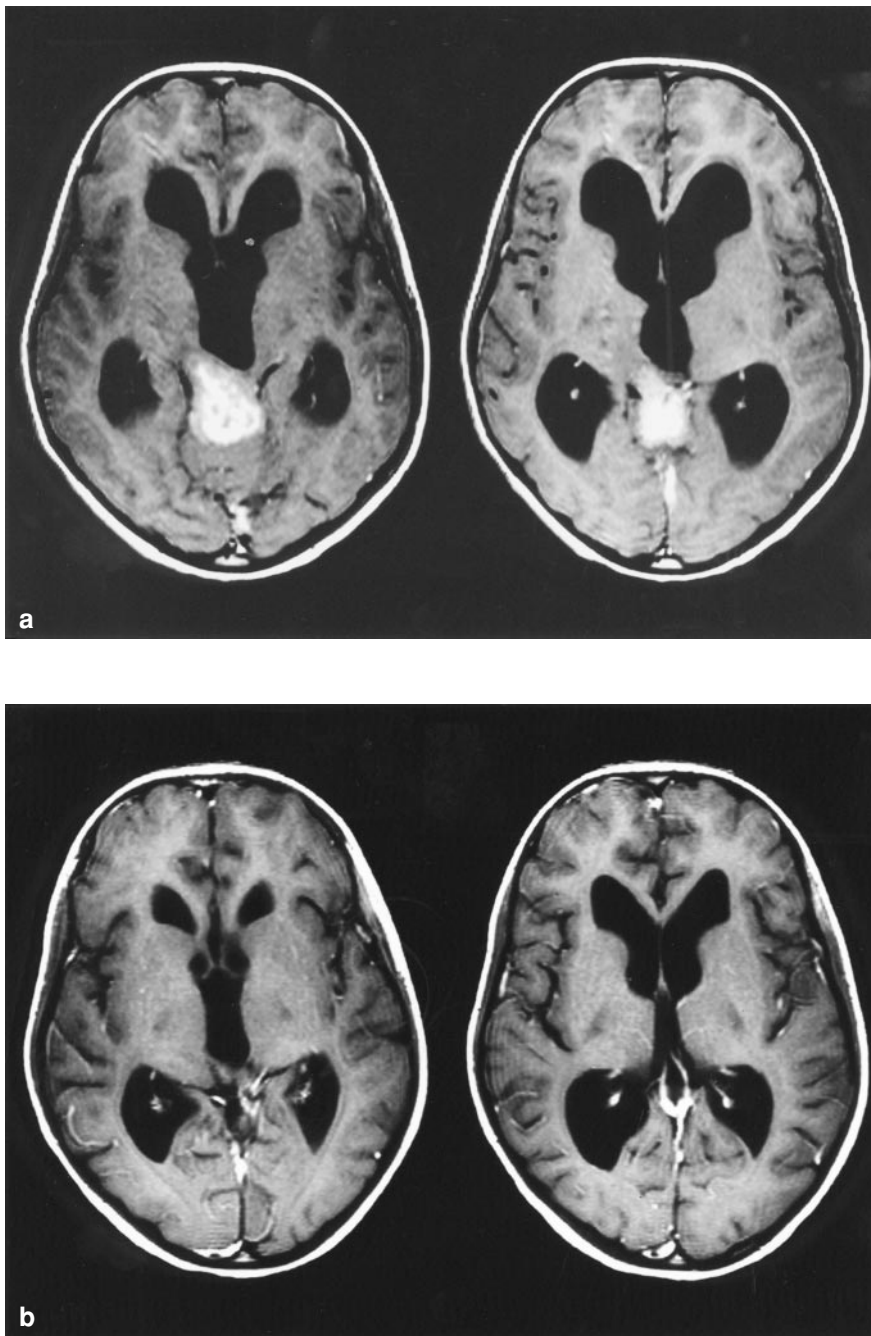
Pre- and postoperative MRI of a 2 cm measuring anaplastic astrocytoma of the right pulvinar thalami in a 10-year old girl (case 13). (a) The preoperative contrast study shows an exophytic, contrast enhancing tumor originating from the habenular insertion. (b) Postoperative contrast MRI showing complete removal of the tumor after an infratentorial supracerebellar approach
